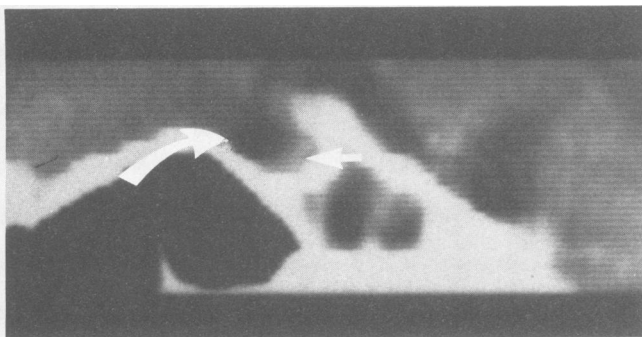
Computed tomography of the head with contrast (diatrizoate meglumine) enhancement. Shown is a lateral computer reconstruction of the sellar area. The curved arrow points to the hypodense empty sella containing a small posterior rim of tissue (straight arrow).
